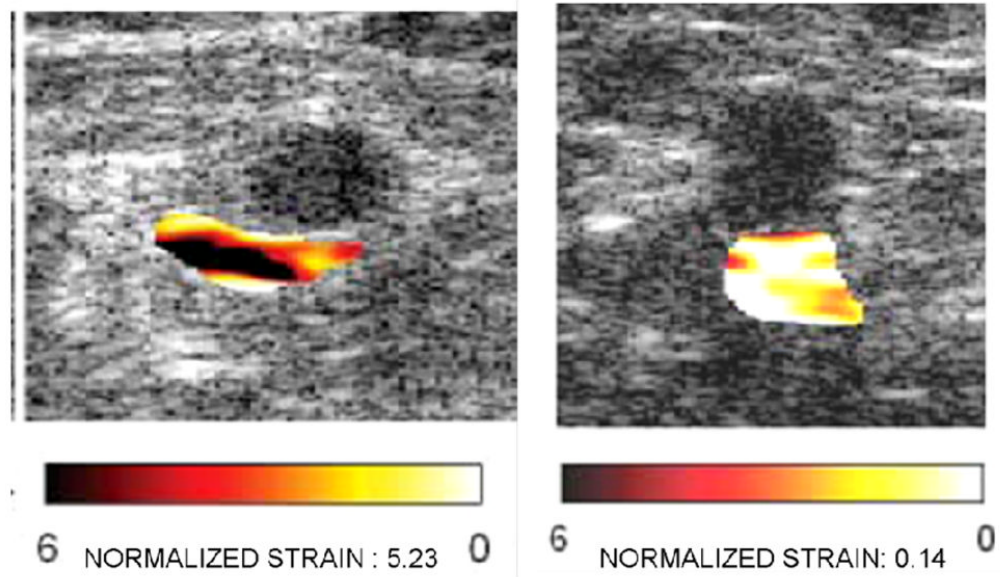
Normalized strain in venous thrombosis. The strain in the vein with chronic thrombosis (right hand image) is much lower than the strain in the more acute thrombosis (left hand image). The echogenicity of the thrombi are nearly identical in grayscale intensity. Images from Rubin JM, et al. J Ultrasound Med 2003;22:443–448.
